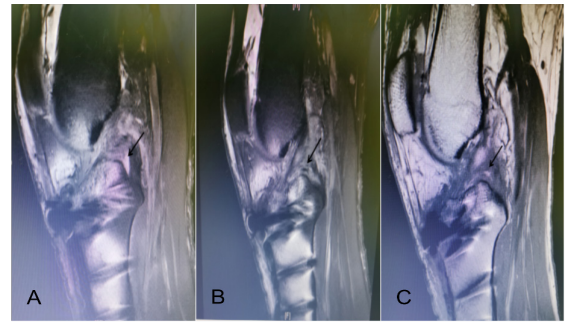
A, B, and C, postoperative left lower limb MRI showed the left quadriceps tendon, posterior cruciate ligament, and popliteal tendon injury in sagittal view. Degeneration of the posterior corner of the medial meniscus and the lateral meniscus of the left knee. "→" indicating damage location.
